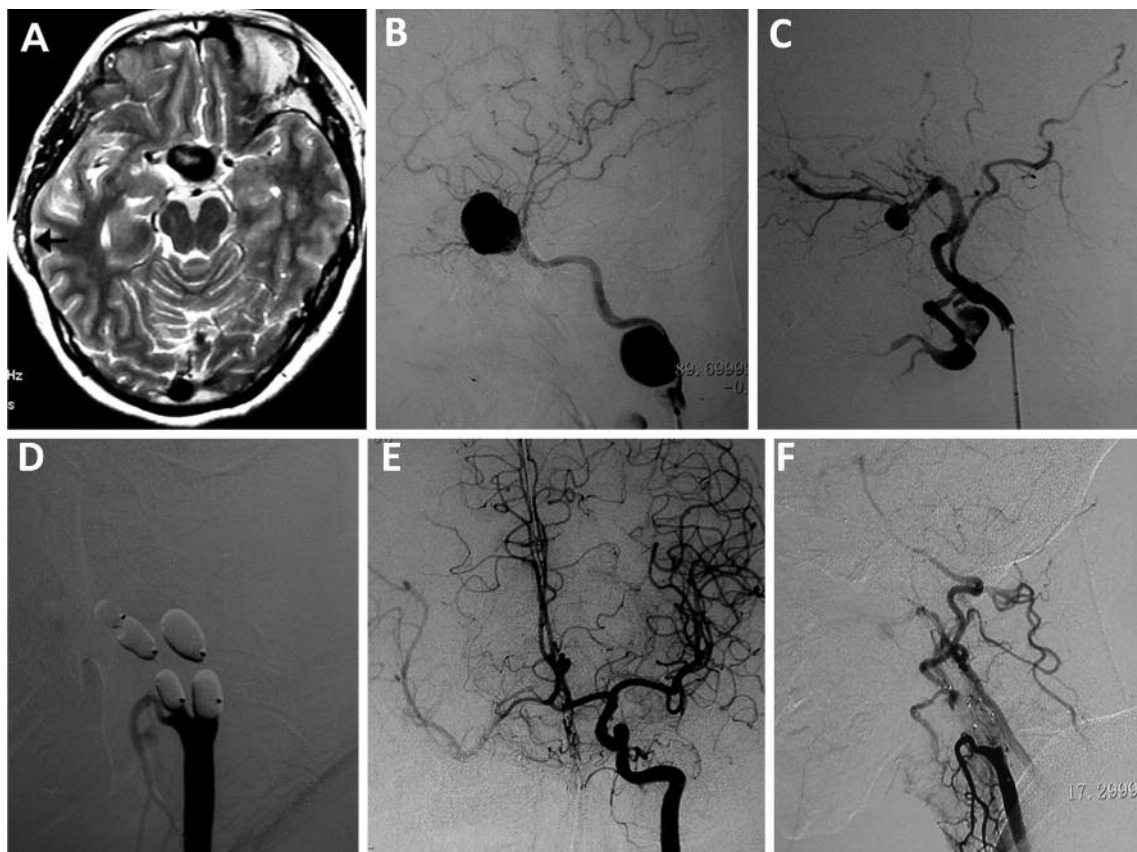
(A) MRI demonstrated an intracranial aneurysm with flow void signs and a doubtful scalp vascular lesion (arrow). (B,C) Angiograms revealed two giant saccular aneurysms of ICA and three aneurysms of ECA. (D) Right ICA and ECA were both occluded by six balloons. (E,F) The follow-up angiogram showed the good filling of right ICA, an anastomosis between superior thyroid artery and VA, and exclusion of the aneurysms.
